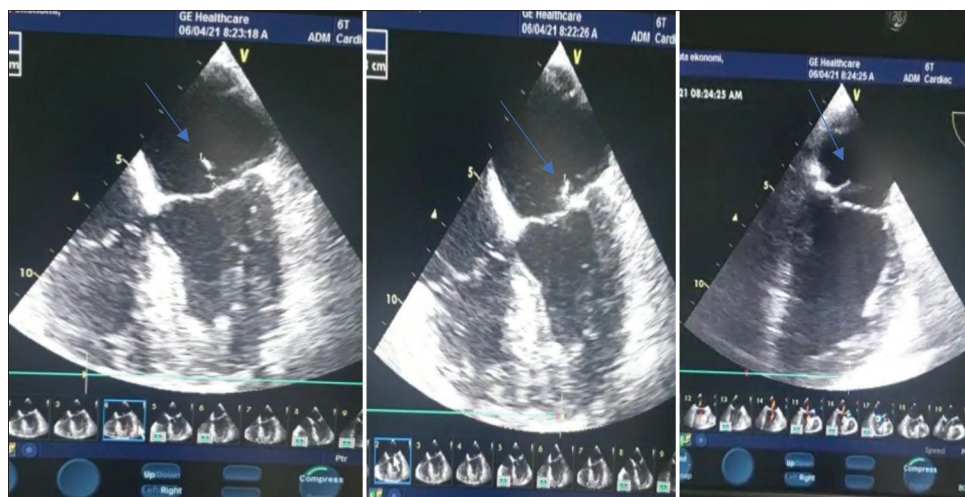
Transesophageal echocardiography. The arrow indicates the filamentous formation
